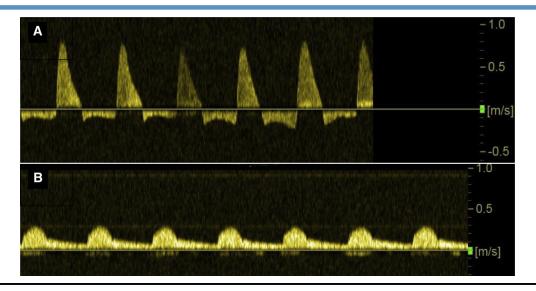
Doppler perfusion pattern of the right renal artery. A, With significant ductal steal, retrograde diastolic flow, steep systolic rise, and elevated systolic pressure. B, Normalized 3 days later after ductal closure with preserved diastolic flow and low velocity.
